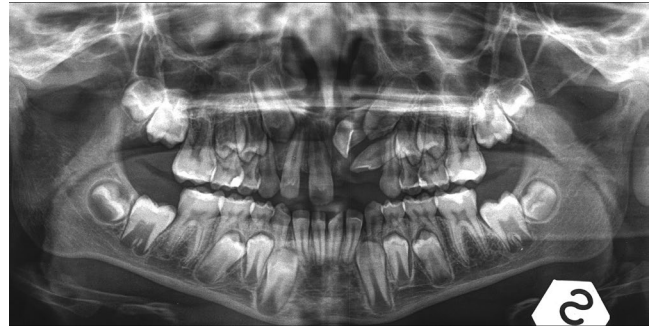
Panoramic radiograph 1 year later, after the extraction of the deciduous central and lateral incisors; the eruption process had begun and the permanent lateral incisor was close to spontaneous eruption in the arch
